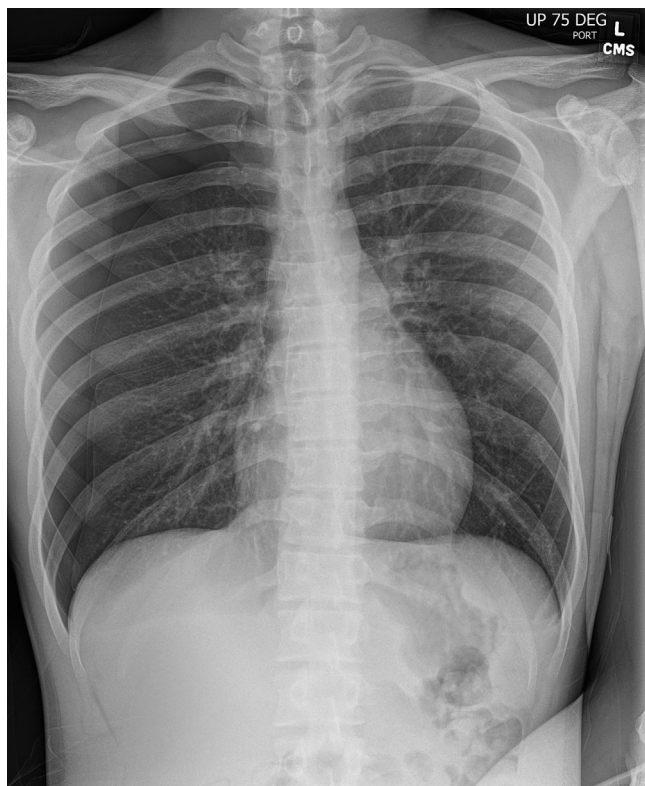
Portable chest radiograph demonstrating a right-sided tension pneumothorax, with mild mediastinal shift.
